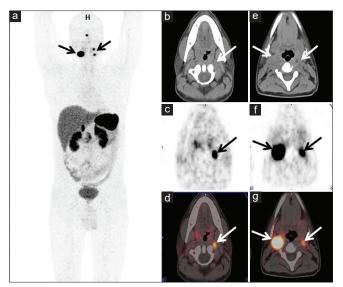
A 24-year-old man operated and histpathologically proven case of paraganglioma in the paraaortic region in abdomen underwent 68Ga-DOTANOC positron emission tomography/computed tomography scan for restaging. Maximum intensity projection image (a) showing intensely tracer avid foci in the bilateral neck regions (arrows). Axial computed tomography, positron emission tomography and fused positron emission tomography/computed tomography (b-d) images showing tracer avid soft tissue lesion (measuring ~ 0.7 cm × 0.9 cm × 0.7 cm, SUVmax 26.8) in the left cervical region along the course of carotid artery (arrows). Axial computed tomography, positron emission tomography and fused positron emission tomography/computed tomography (e-g) images showing tracer avid soft tissue lesions along the course of bilateral carotid arteries (right cervical region: measuring ~ 2.0cm × 2.2 cm × 2.8 cm, SUVmax 152.6; left cervical region: measuring ~ 0.6 cm × 1.0 cm × 0.8 cm, SUVmax 35.3) (arrows). He was operated again and verified as right & left synchronous carotid body paraganglioma on HPE
